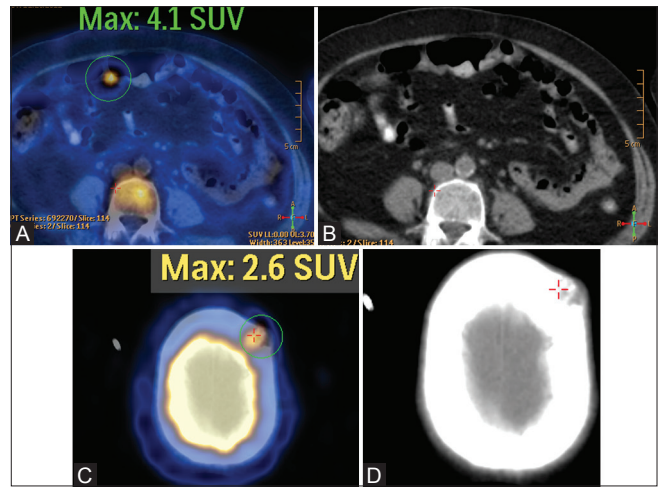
(A–D): A 62-year-old lady presenting with elevated CEA (5.2 ng/ml). A hypermetabolic focus was found at the mid-transverse colon on fusion PET/CT (A), which persisted in delay image (not shown). No obvious lesion was found on plain CT (B). Another hypermetabolic lesion was found at the left frontal skull on fusion PET/CT (C), corresponding to a destructive bone lesion on CT (D). Features were consistent with a small colonic tumor with skull metastasis
